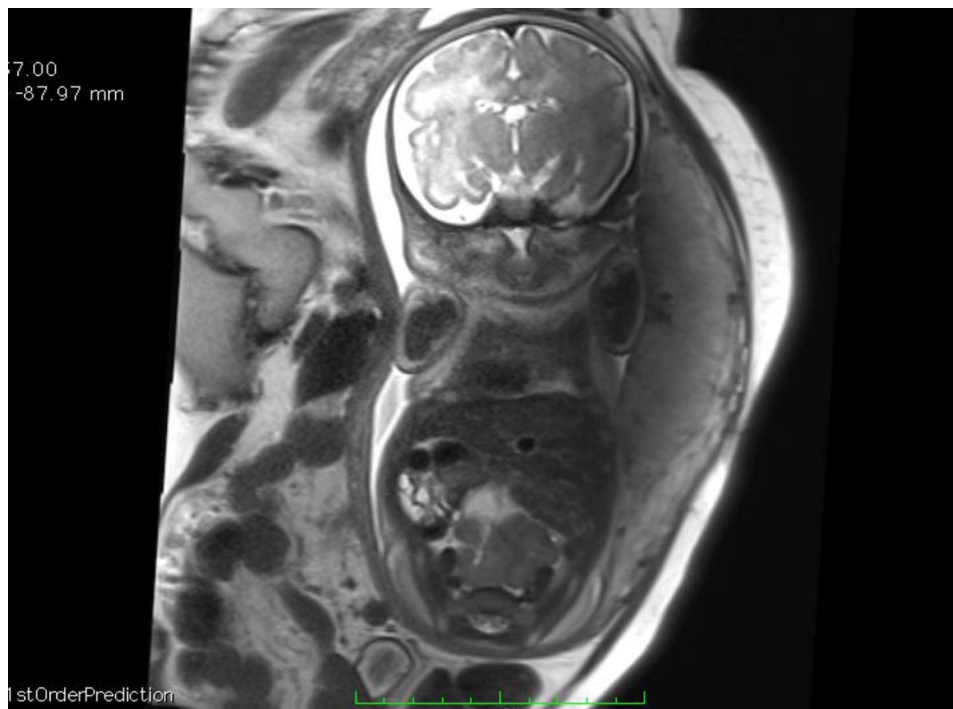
MRI of the same fetus in an axial and coronal plane shows a centrally placed fused pancake kidney lying in the pelvic cavity, posterior to the urinary bladder
